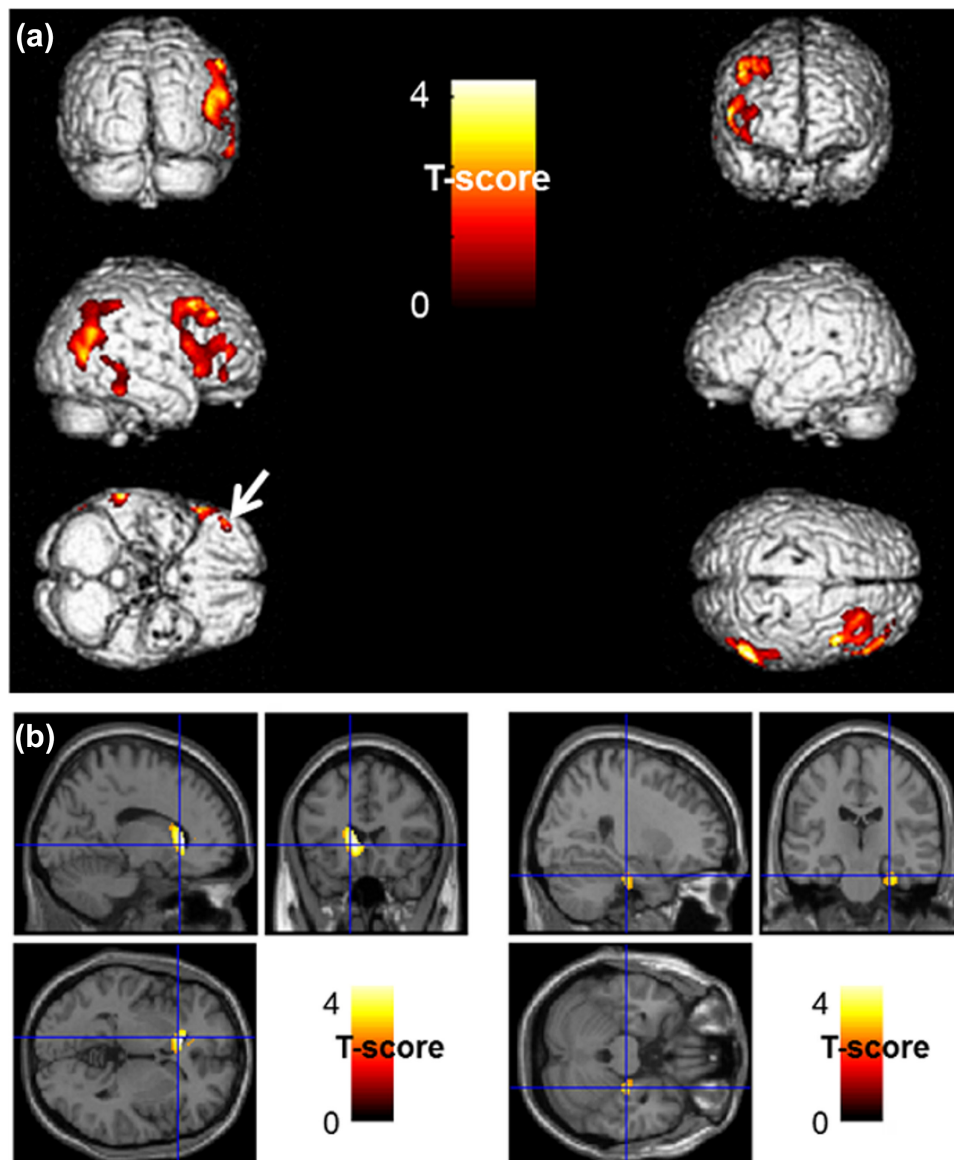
Anatomical localization of areas of increased positive (upper panel in a) and negative (lower panel in b) right BA20–21 connectivity in ICD patients in comparison to those without ICDs ($p < .005$, uncorrected, $k > 130$) projected onto 3D volume rendering (a) and sections of a normal MRI (b) set spatially normalized and smoothed into the standard SPM8 template. ICD patients showed an increased positive connectivity in right middle temporal gyrus (BA20–21–22), right middle and superior temporal gyri and parietal inferior lobule (BA37–39–40) and right middle and inferior frontal gyri (BA9–10), including the orbito-frontal area (BA11) (white arrow) (a). Moreover, ICD patients showed an increase negative connectivity with the left caudate (left panel), and with the right parahippocampal gyrus (BA35–36, right panel) (b). BA: Brodmann area; ICD: impulse control disorder; MRI: magnetic resonance imaging [Color figure can be viewed at wileyonlinelibrary.com]
